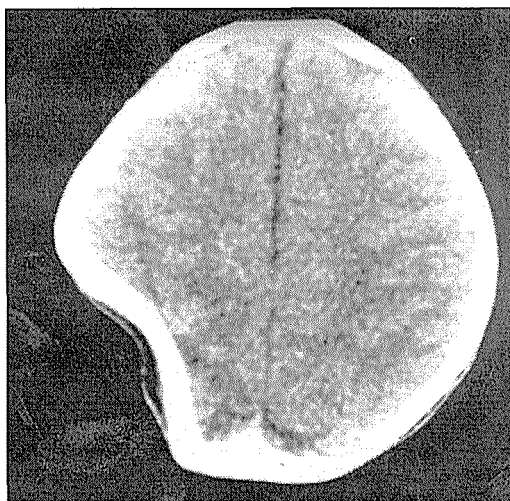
CT scan showing a congenital parietal depression.
